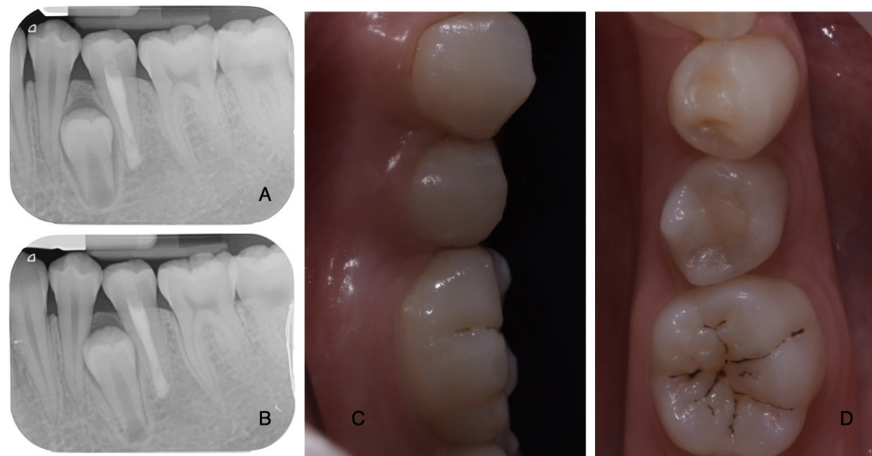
Radiographic evidence indicating ongoing root development at the 6-month follow-up from the initial evaluation (A), with full completion of root development observed after 3 years from the commencement of the initial treatment (B). Clinical 3-year follow-up revealed that the supernumerary immature tooth was healthy with an increased root development and correctly positioned in the arch (C, D).
